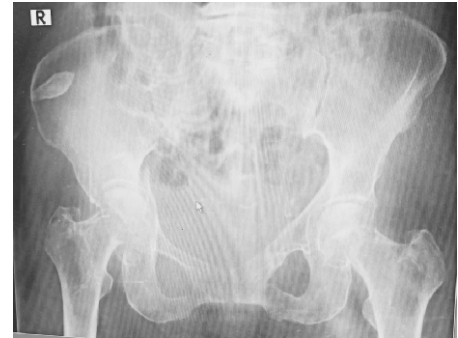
Radiographic image of right acetabular fracture.
